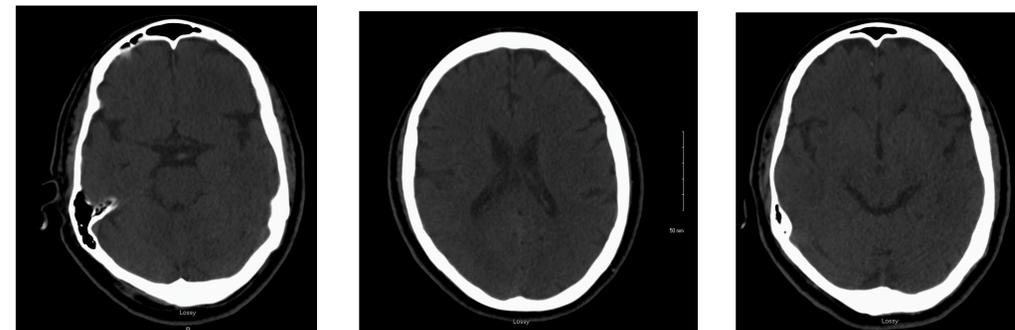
CT head negative for stroke.
